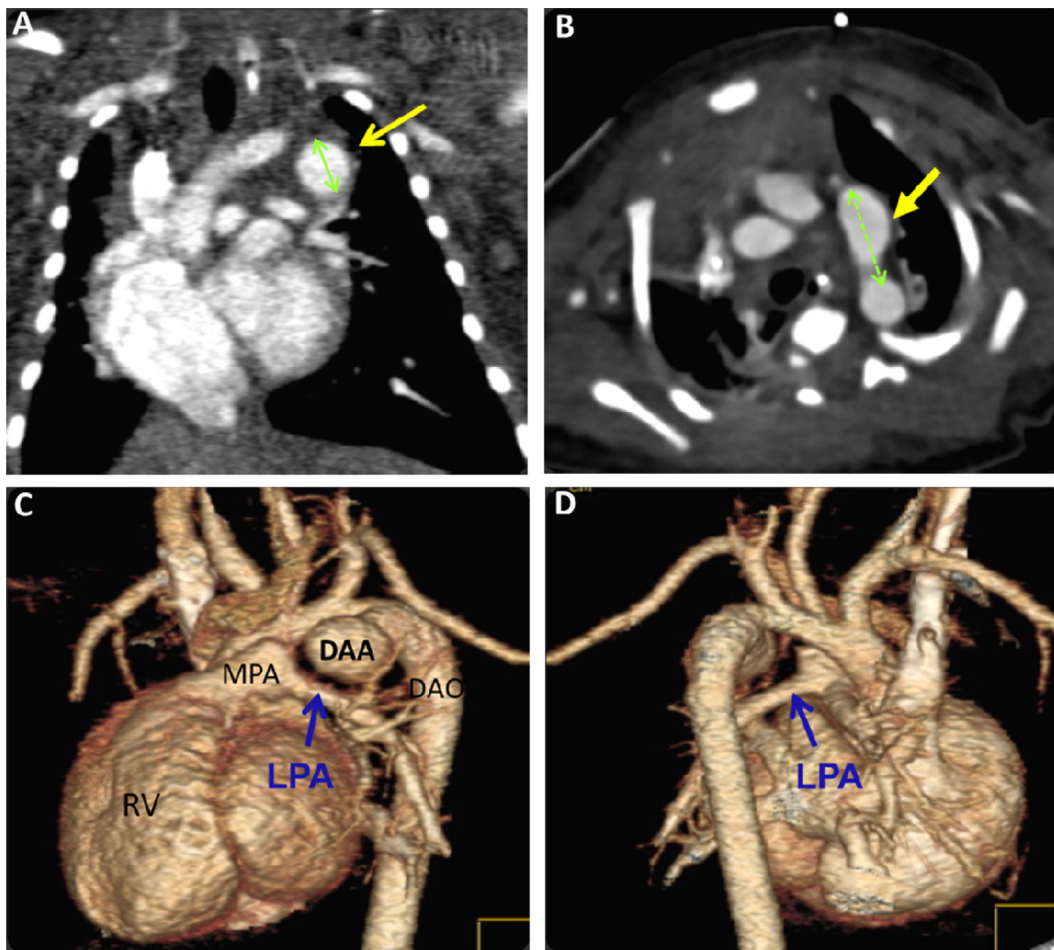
(A) Computed tomography shows a large DAA with a diameter of 8.48 mm; (B) DAA with a length of 17.02 mm; (C, D) three-dimensional computed tomography showing DAA arising from the descending aorta with a closed end at the pulmonary artery side. No compression of the adjacent structure. DAA = ductus arteriosus aneurysm; DAO = descending aorta; LPA = left pulmonary artery; MPA = main pulmonary artery; RV = right ventricle.
